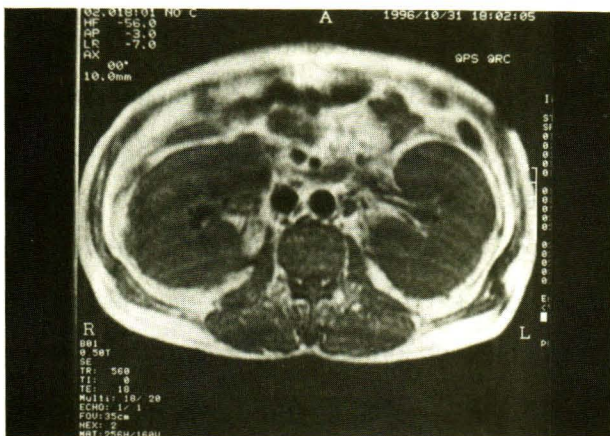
Renal Magnetic Resonance Imaging studies, performed on admission, showed bilaterally enlarged kidneys; the right kidney measured 17 cm. and the left kidney 19cm.
